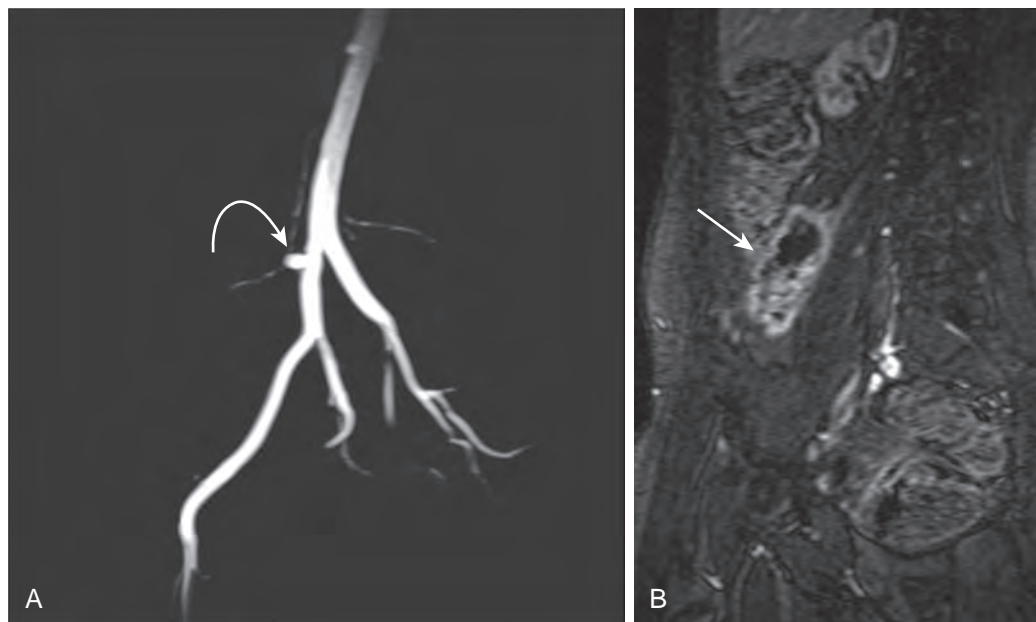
Chronic arterial graft thrombosis due to chronic rejection in a 53-year-old woman. A. Subtracted MRA shows the stump (arrow) of the occluded graft artery. B. Coronal postcontrast fat-suppressed T1-weighted MR image shows that the pancreas (arrow) is largely infarcted with rim enhancement. (From Vandermeer F, Manning MA, Frazier A, et al: *Imaging of whole-organ pancreas transplants*. *RadioGraphics* 32:411–435, 2012.)
